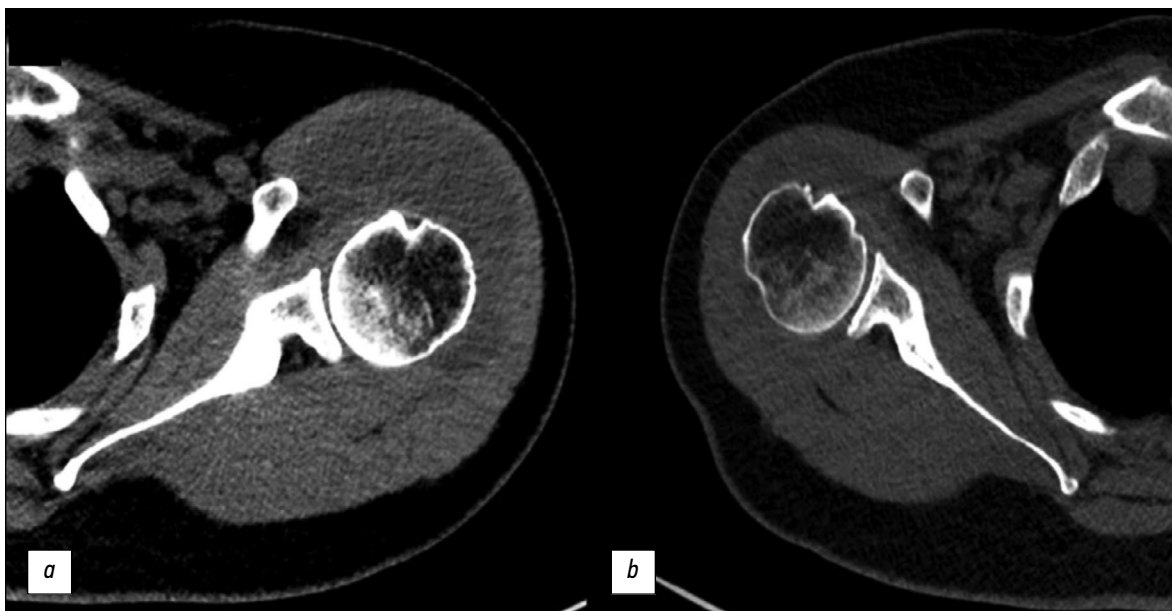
Computed tomography of the shoulder joints, axial view: *a*, left shoulder joint; *b*, right shoulder joint.
